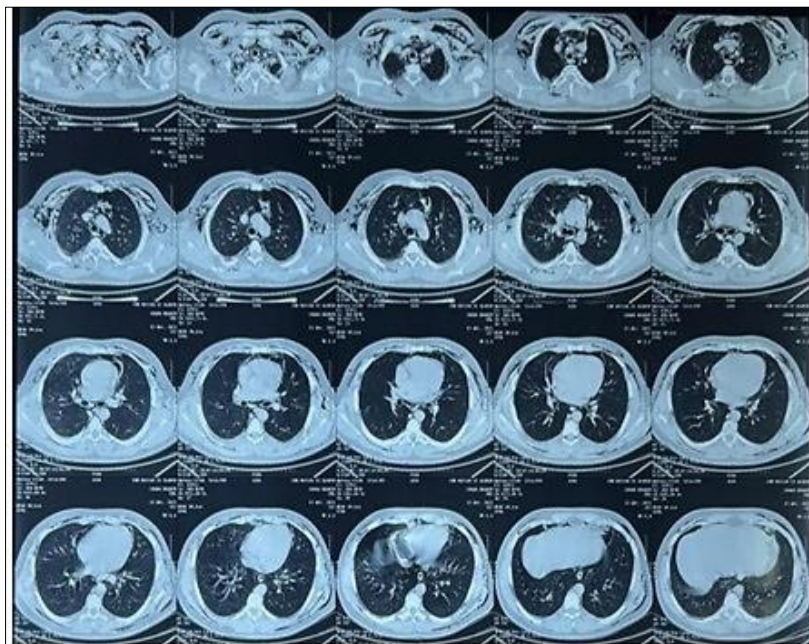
Chest CT showing the presence of interstitial air surrounding the mediastinal structures, important subcutaneous emphysema
